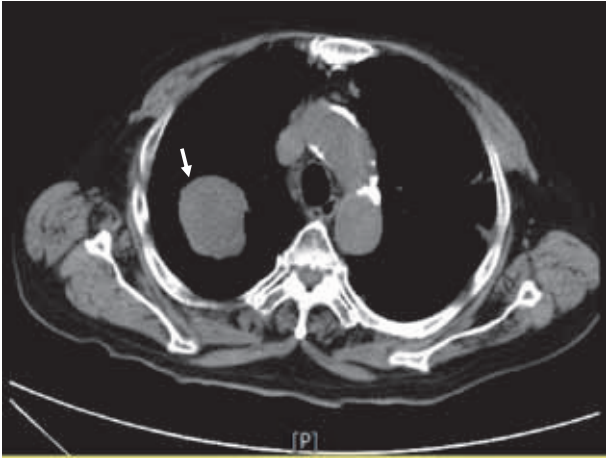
Computed tomography of the chest. A hyperdense mass with irregular margins measuring 7.5 m (arrow) in diameter can be observed in the right upper lobe of the lung.
